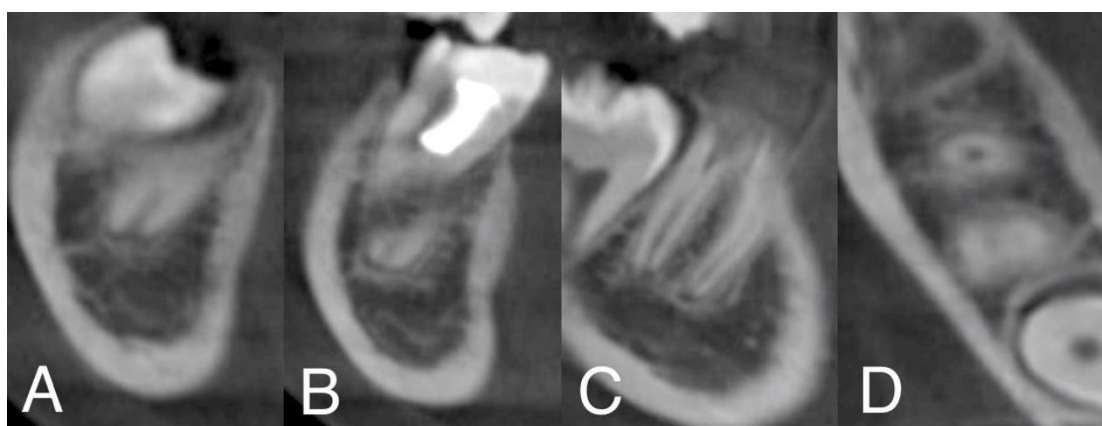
During 3rd appointment. CBCT radiography showing the almost closed apex in different planes
